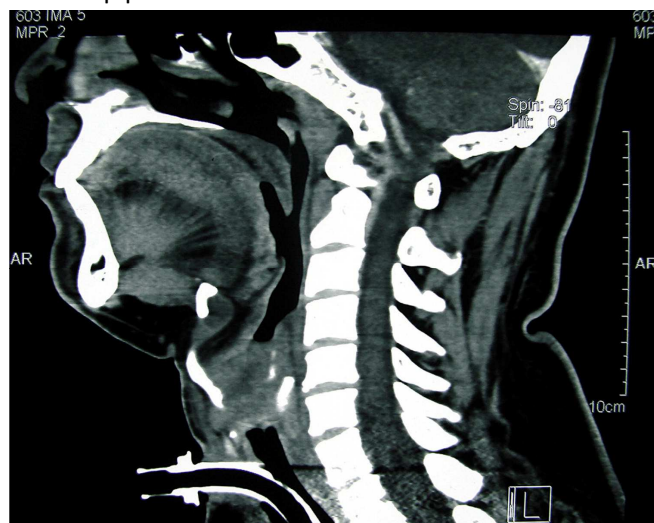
Sagittal section of CT scan of the neck showing heterogeneously enhancing soft tissue growth in the larynx occluding the airway.
